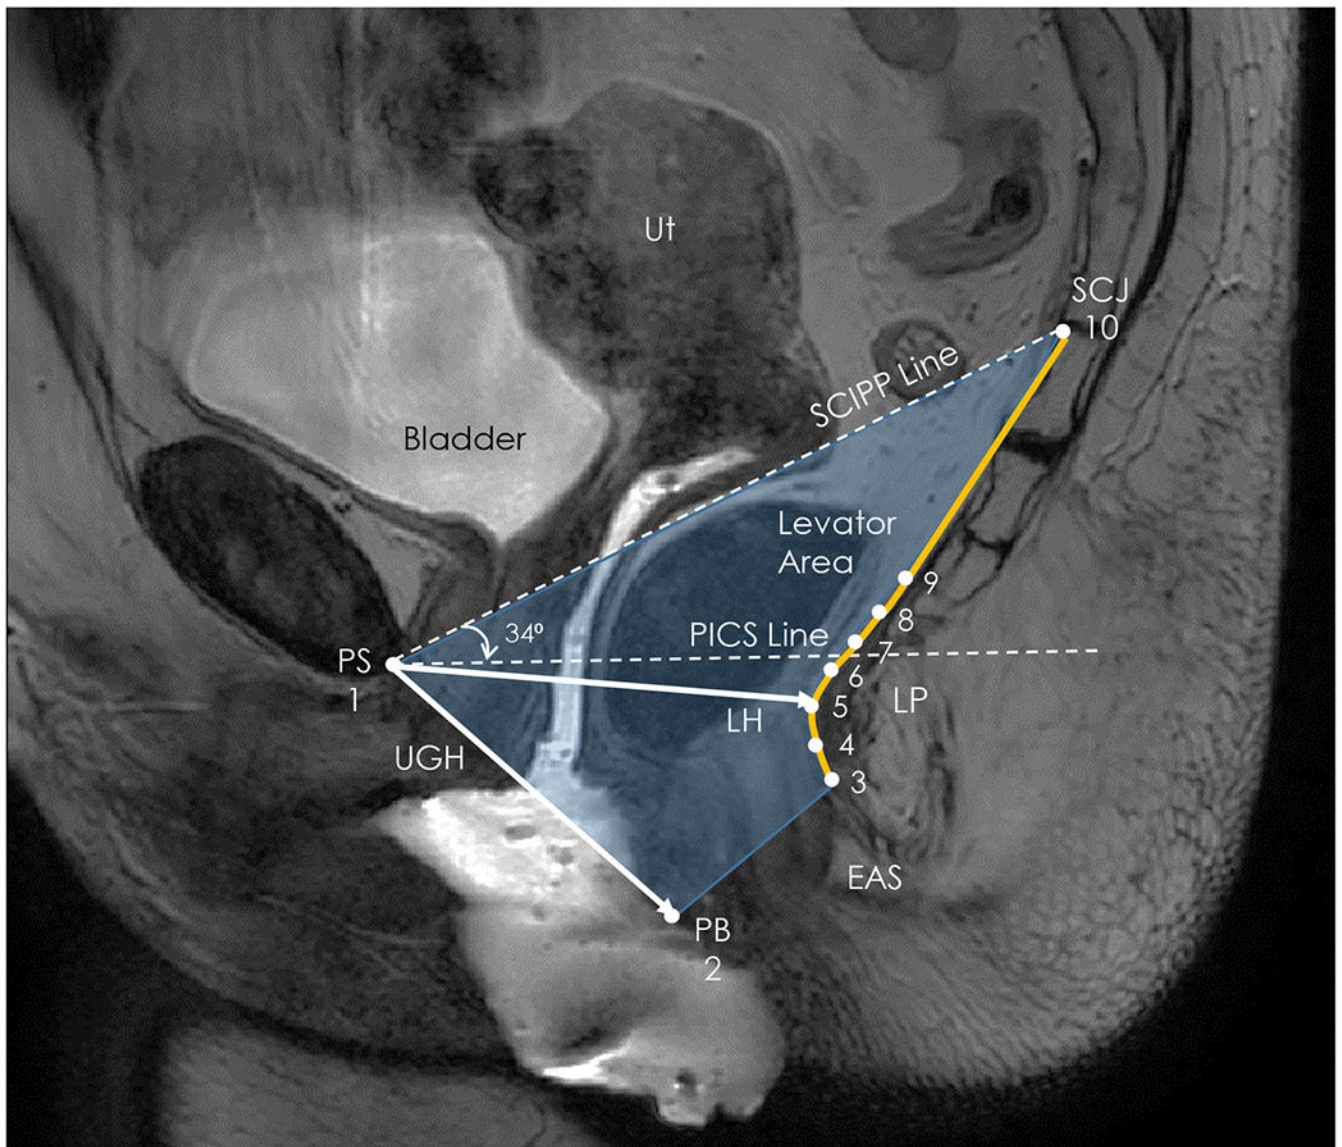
Mid-sagittal MRI measurements
